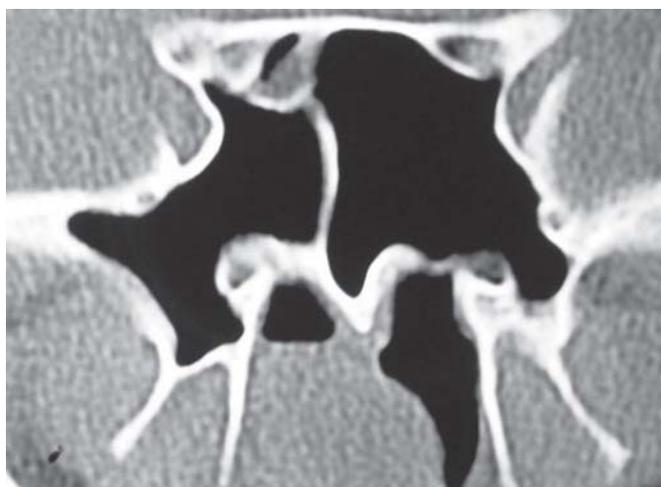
Coronal CT scan of the paranasal sinuses showing a type III optic nerve running through the Onodi cell
